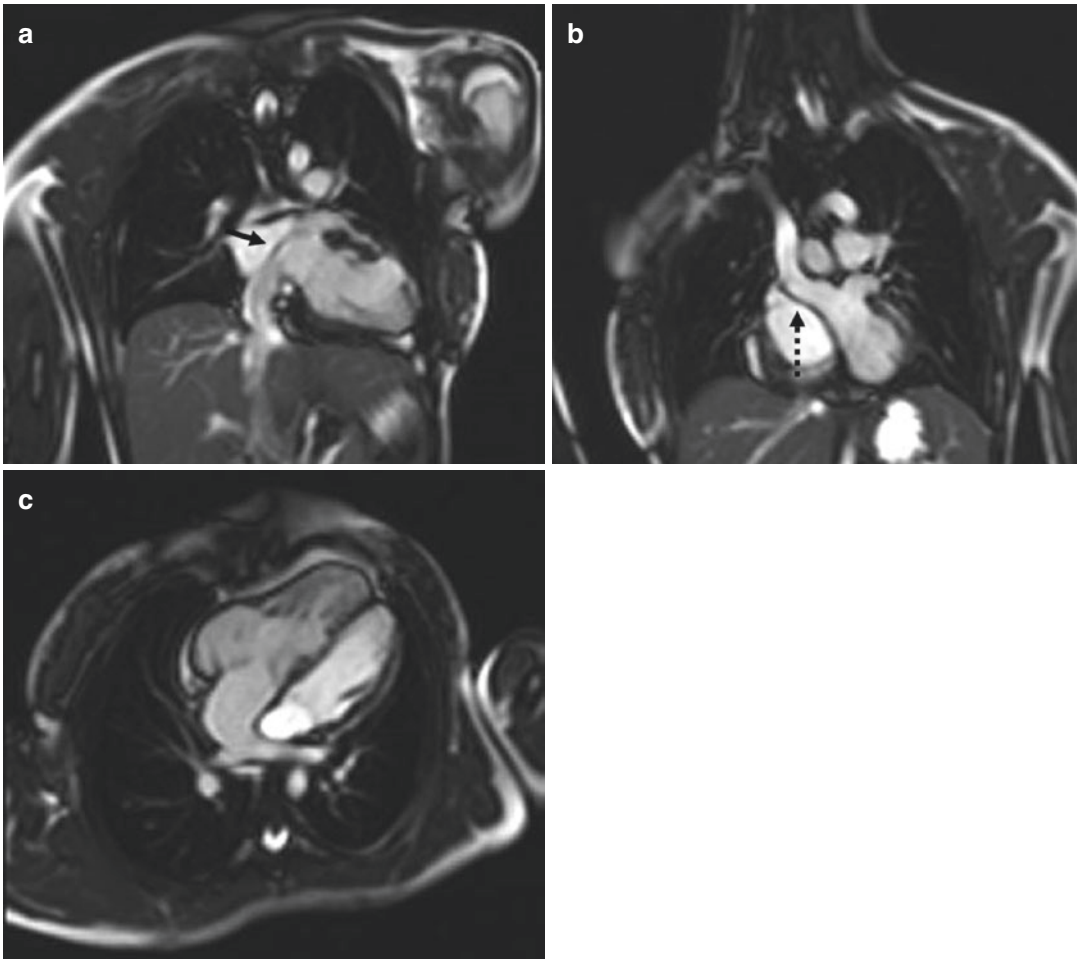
Atrial switch (Mustard procedure) for D-transposition of great arteries at cardiac MRI. (a), (b) Coronal oblique cine TruFISP MRI sequence images demonstrate drainage of right superior (*black dotted*
